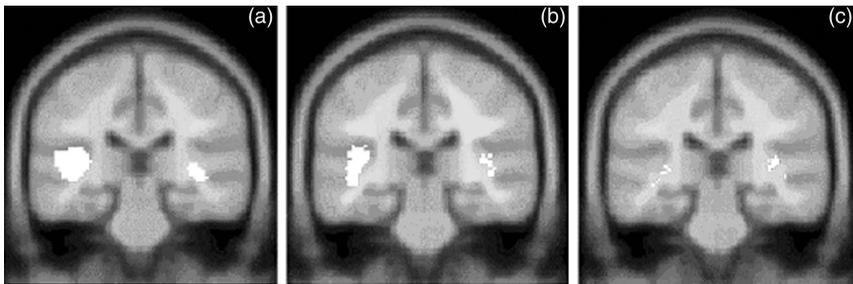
(a): brain areas showing an increase in regional cerebral blood flow during auditory stimulation in controls. (b) and (c): areas of increase of rCBF during auditory stimulation that are common to controls and respectively MCS patients (b) and VS patients (c). Results are projected on a coronal section of a normalised brain MRI template, 28 mm posterior to the anterior commissural line
